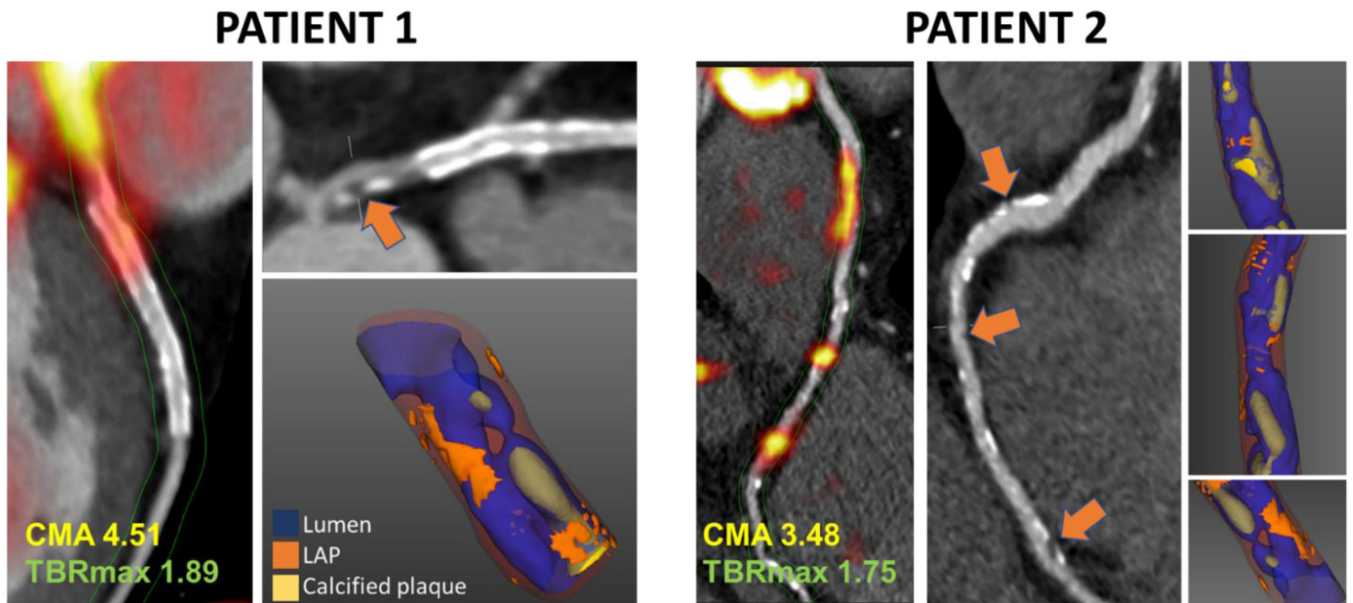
Case examples of coronary ^{18}F -sodium fluoride uptake, low attenuation plaque (LAP) on CT angiography and LAP (orange arrows, II) on 3D CT rendering (III). Right (Patient 1) and left anterior descending (Patient 2) coronary arteries. Areas of LAP correspond with areas of increased ^{18}F -NaF activity. While maximum target-to-background ratio (TBRmax) reflects single hot-spot activity coronary microcalcification activity (CMA) values represent the whole-vessel ^{18}F -sodium fluoride burden.
